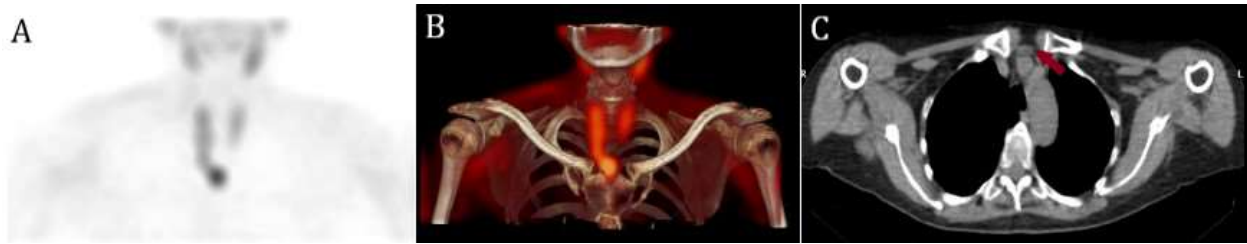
Tc-99m sestamibi SPECT/CT in a 56-year-old patient with ectopic parathyroid adenoma
